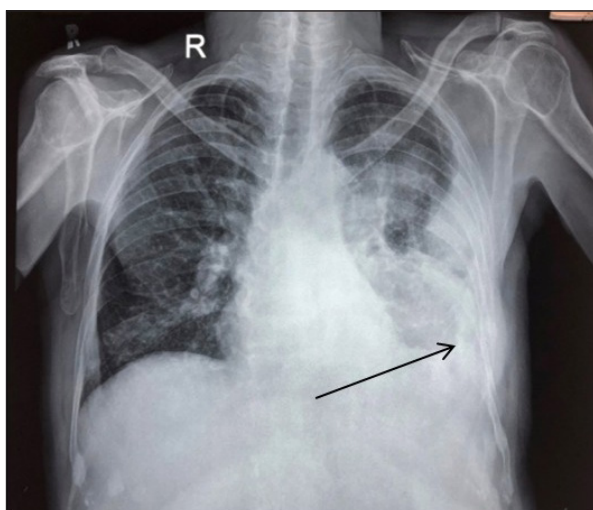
Chest-X-ray showing massive pleural effusion with blunting of costophrenic angle on the left side (black arrow).
